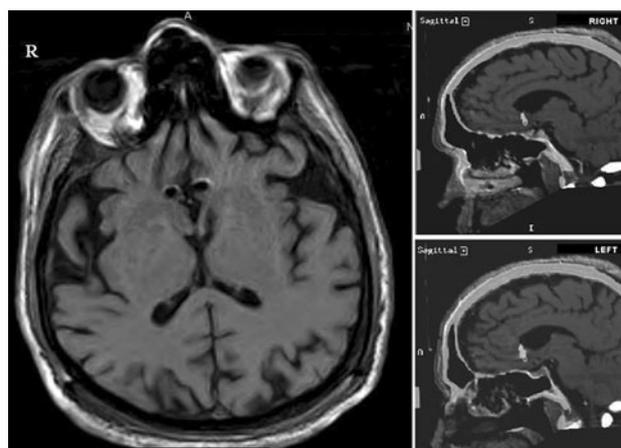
Postoperative MRI showing the axial section with bilaterally implanted DBS leads in the Brodmann's area 25 (subgenual cingulate cortex) in a patient affected by major depression. The *right panel* displays the sagittal view of both sides
